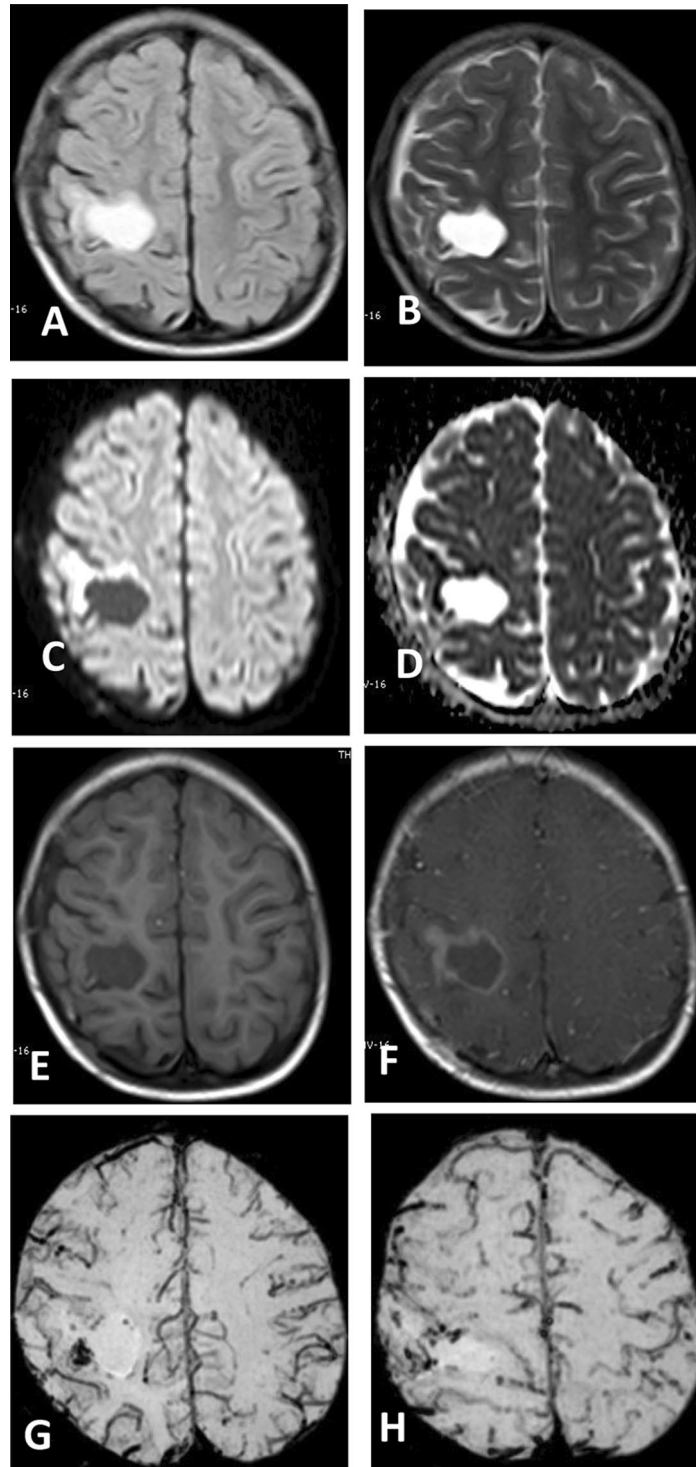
A 5-year-old female child presenting with high-grade supratentorial ependymoblastoma. A Axial FLAIR and B T2WI show right high frontal space-occupying lesion of bright signal. C Axial DWI and D ADC show a rim of restricted diffusion with low ADC value measuring $0.99 \times 10^{-3} \text{ mm}^2/\text{s}$. E Axial T1WI shows low signal mass. F Axial post-contrast T1WI shows rim enhancement with mural nodule along its lateral border. G, H SWI shows prominent vascularity particularly along its lateral aspect with more than 10 foci of hypointense signal (ITSS score 2)
